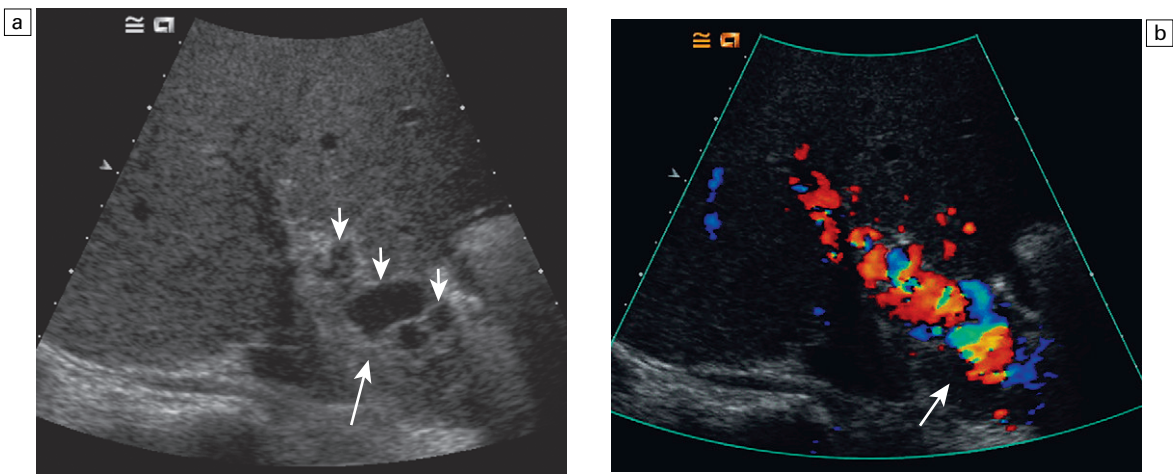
With long-term portal vein thrombosis the presence of cavernous transformation may be confirmed, ‘Doppler rescue’; (a) baseline imaging demonstrates a dilated high reflective portal vein (arrow) and serpiginous low reflective structures (small arrows) in keeping with cavernous transformation; (b) following SonoVue®, the cavernous transformation and the occluded portal vein (arrow) are demonstrated.
